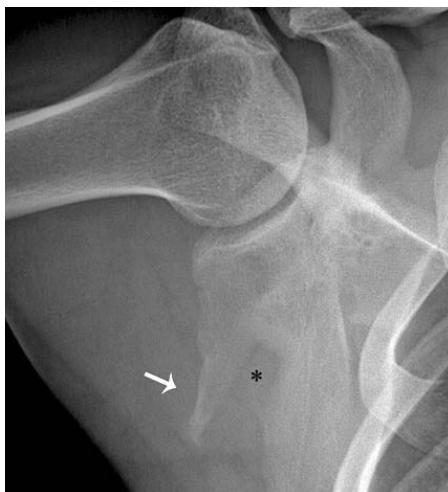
An initial radiograph obtained on the day of injury reveals a complete vertical fracture of the neck of the scapula and axillary border of the scapula with a 2 cm lateral displacement of the entire glenoid process and a triangular fracture fragment that project inferiorly and laterally into the axilla (white arrow).
